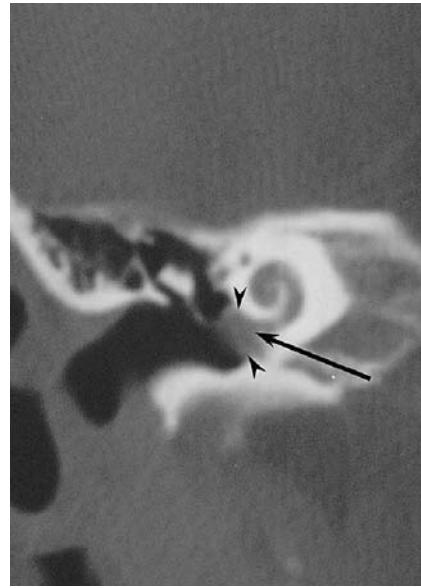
Persistent stapedial artery. Coronal bone-window CT demonstrates a mass (arrowheads) in the medial mesotympanum. Adjacent images show the mass to be tubular in configuration. The abnormal structure divides and widens the crura of the stapes, and passes over the cochlear promontory (arrow)
